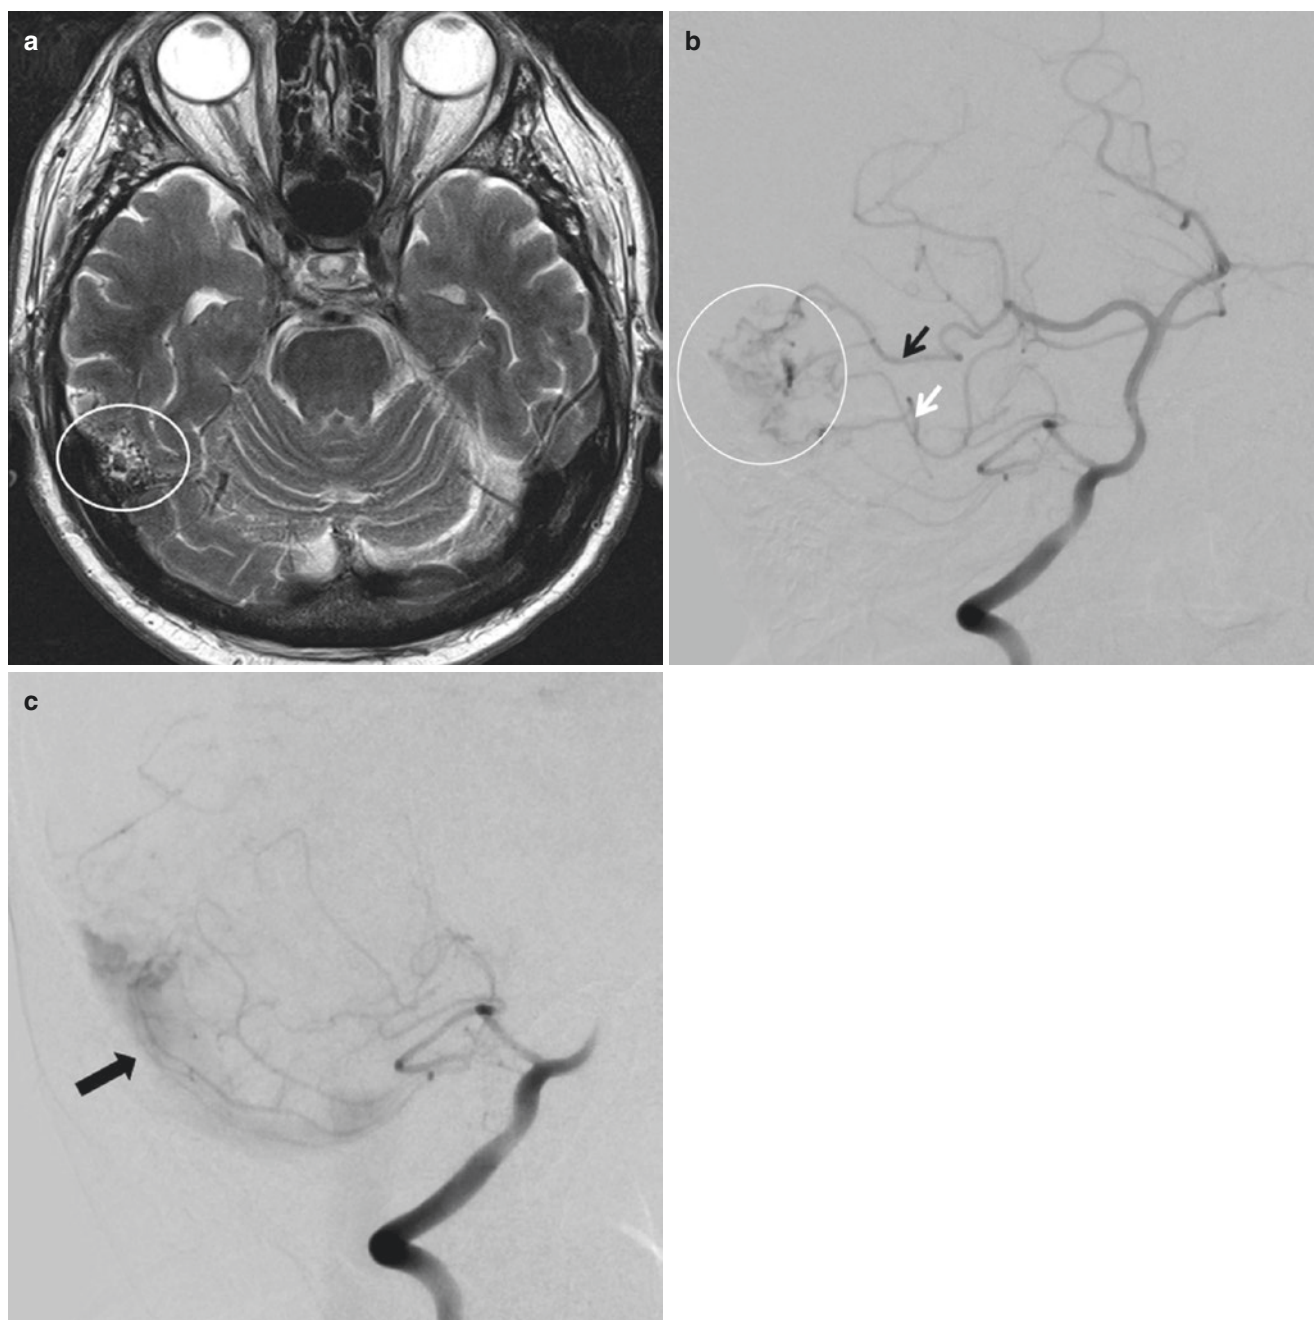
Borden type I sigmoid sinus DAVF. Patient with headache and tinnitus presents to ER. (a) Axial T2 MRI shows a cluster of abnormal flow void in the right temporal lobe, suspicious for a vascular malformation. (b) Oblique view of catheter angiogram during arterial phase of right vertebral injection shows an AV fistula supplied by the distal right
